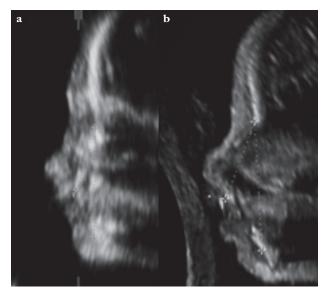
Ultrasound pictures of cases with UCL/P. Case 12 (A) with trisomy 21 and normal (15.0°) MNM angle. Case 33 (B) with isolated UCL/P and largest (26.2°) MNM angle in UCL/P group.
